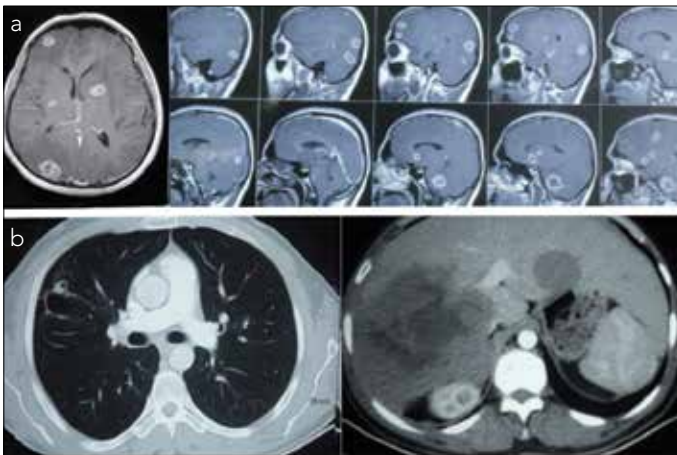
a-b. Contrast-enhanced multiple brain lesions are supra- and infratentorially present on T1-weighted MRI (a); some other lesions are observed in the right lung and in the liver (b)
